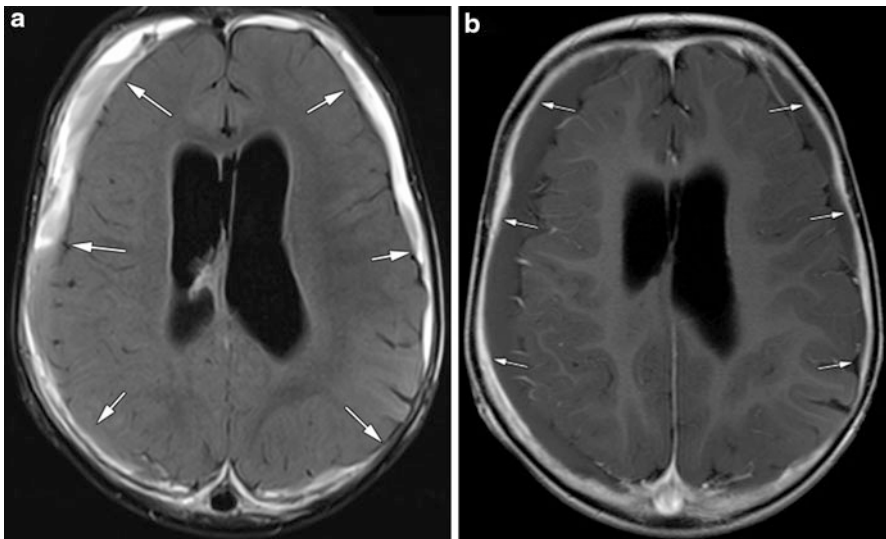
Chronic SDH with enhancing fibrovascular granulation tissue. An MRI FLAIR image (a) demonstrates bilateral SDH with blood products of various ages (*white arrows*). On postcontrast imaging (b) there is a thick rim of enhancing tissue along the outer margins of the SDHs bilaterally consistent with fibrovascular granulation tissue (*white arrows*)
